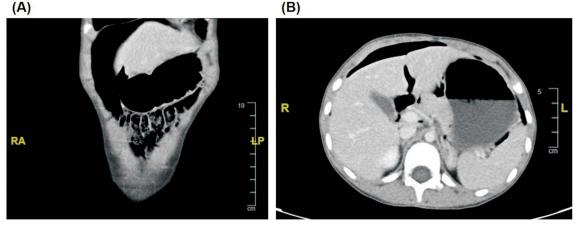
Axial and coronal views of the abdominal computed tomography showed massive pneumoperitoneum.
